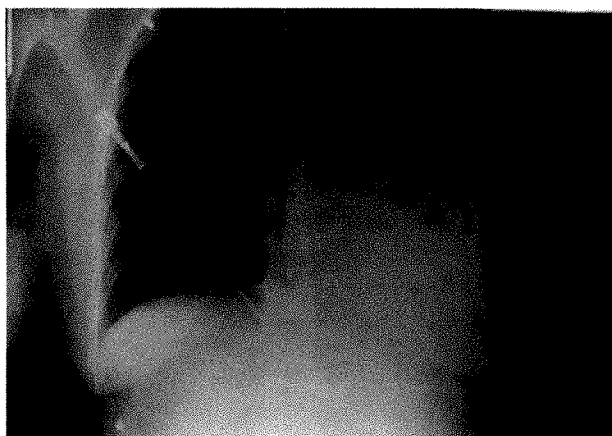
Emergency room chest radiograph showing slightly elevated left hemidiaphragm.
